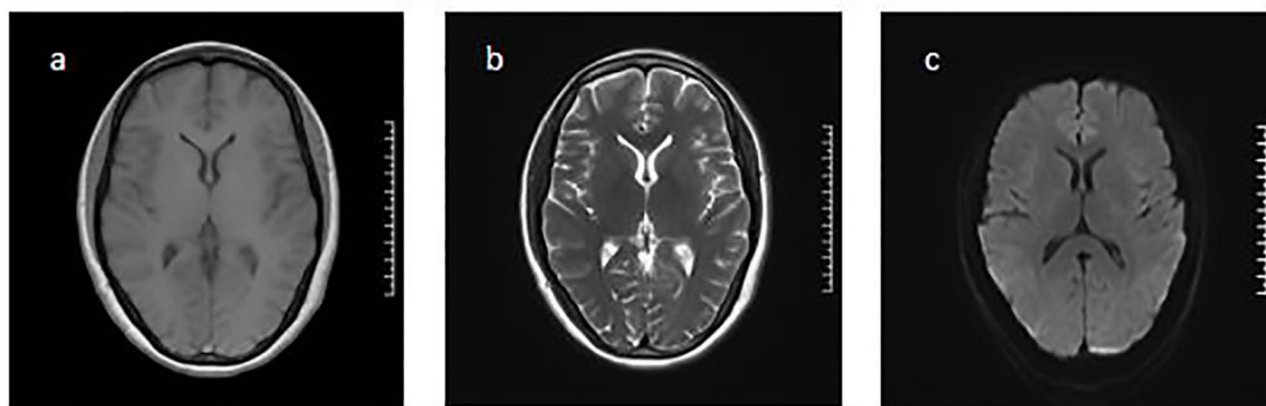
Brain magnetic resonance imaging. (a) No positive results were found in the T1 sequence; (b) no positive results were found in the T2 sequence; (c) no positive results were found in the DWI
